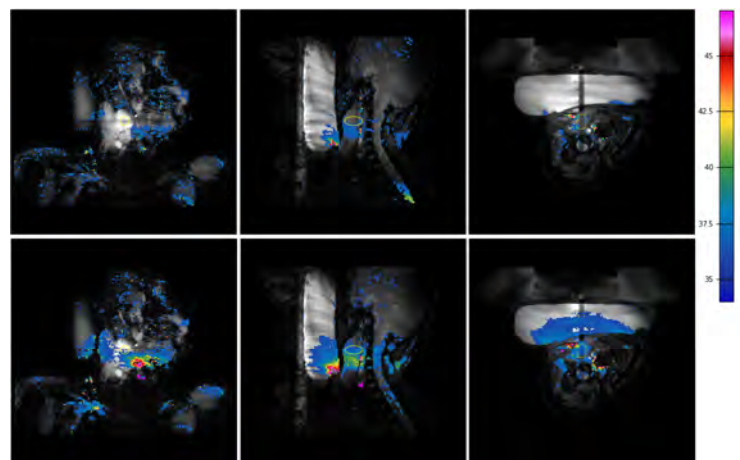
Overlay of thermal maps on magnitude images on coronal (left), sagittal (center) and transverse (right) planes with (top row) and without (bottom row) motion compensation. Temperature below 38 degrees was masked. Region of interest of focused ultrasound are encircled by a yellow line.
